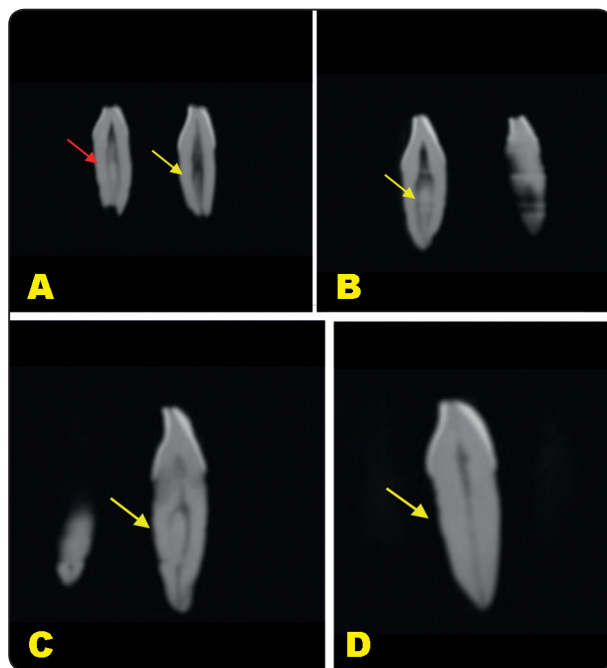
(A) Cone beam computed tomography (CBCT) showing I1 with type I (yellow arrow) and type II (red arrow) root canal configuration, (B) CBCT showing I2 with type II (yellow arrow) root canal configuration, (C) CBCT showing I2 with type III (yellow arrow) root canal configuration, (D) CBCT showing I2 with type I (yellow arrow) root canal configuration.
